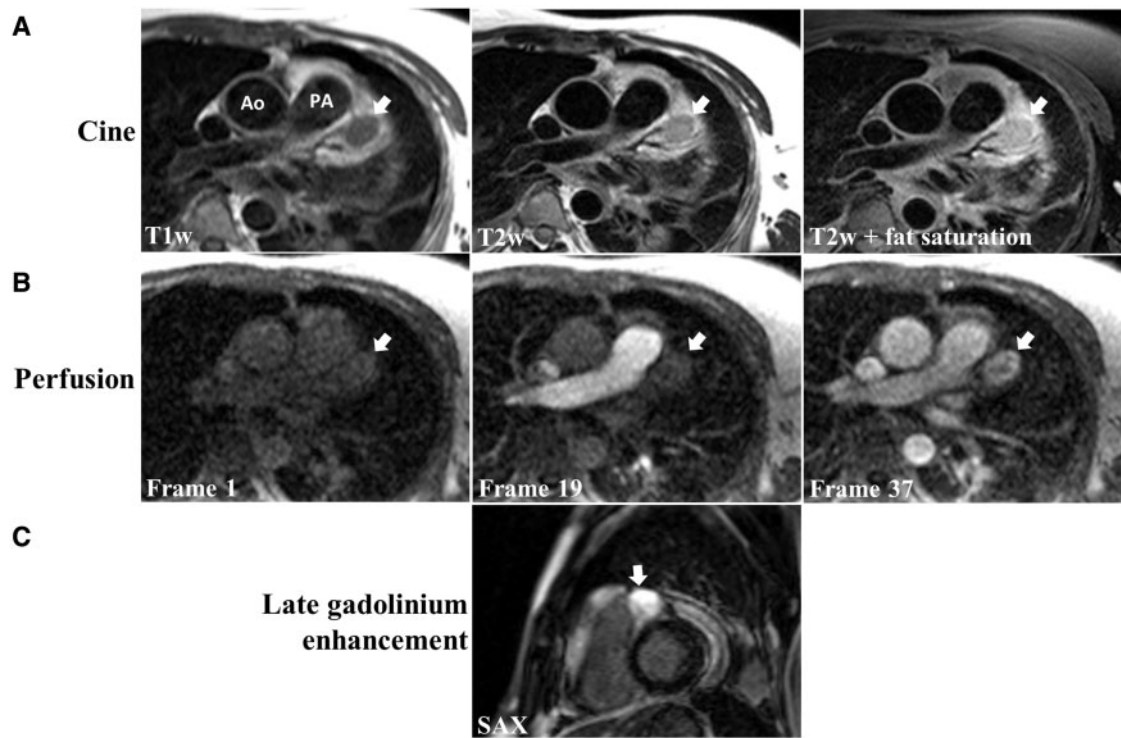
(A) Tumour (arrows) demonstrates isointense signal in T1-weighted (left) and hyperintense signal in T2-weighted (middle) images. Fatty tissue could be ruled out by fat saturation (right). Representative images of cardiac magnetic resonance imaging first-pass perfusion (B) depict early peripheral perfusion of the mass (see also [Supplementary material online, File S4](#)). Late gadolinium enhancement (C) sequence shows intense enhancement after 5 min. Ao, ascending aorta; PA, pulmonary artery; SAX, short axis; T1w, T1-weighted; T2w, T2-weighted.
